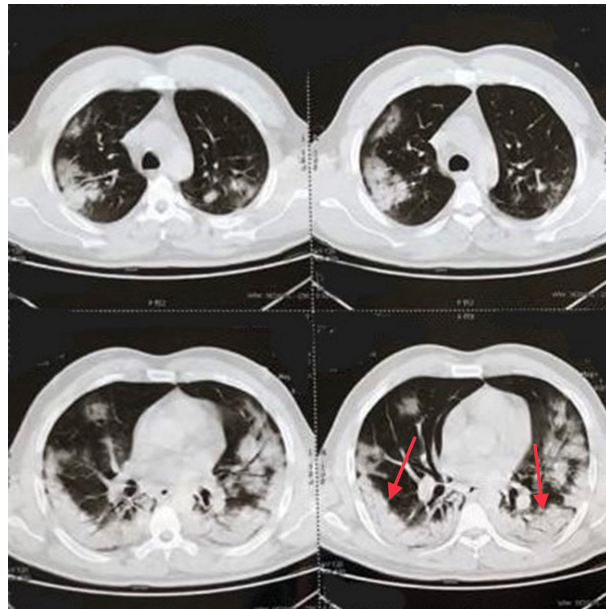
Thoracic CT scan of a 25-year-old male patient during his COVID-19 showing bilateral extensive ground-glass opacities (red arrows).
